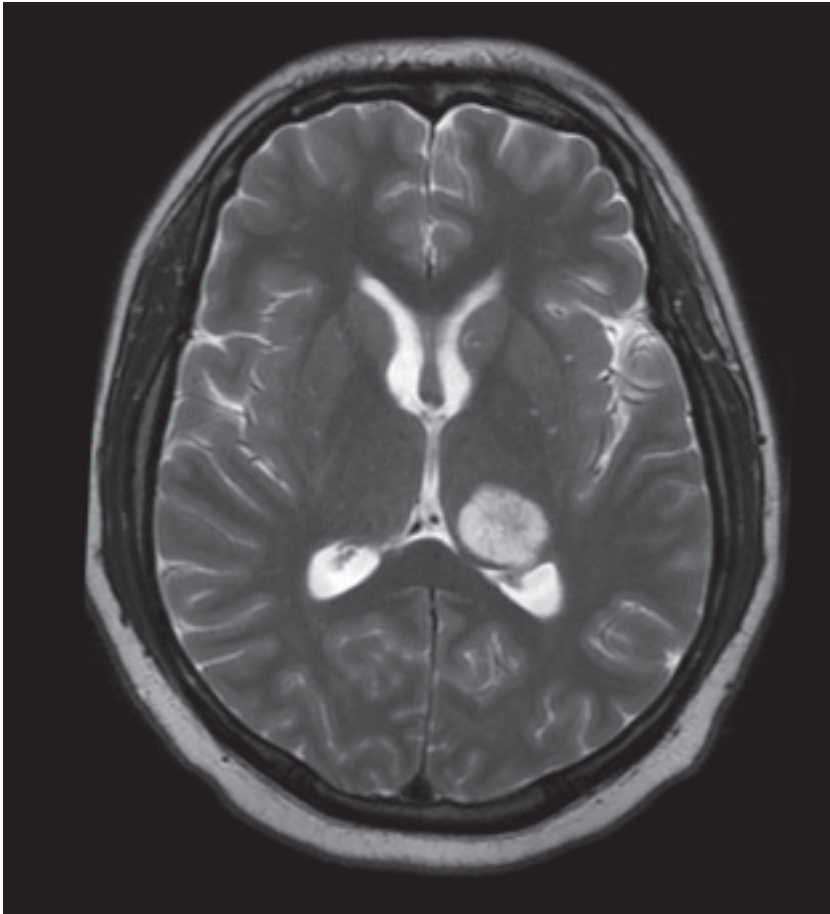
Image from T2-weighted MRI scan of head showing left thalamic cryptococcoma and leptomeningeal involvement.
